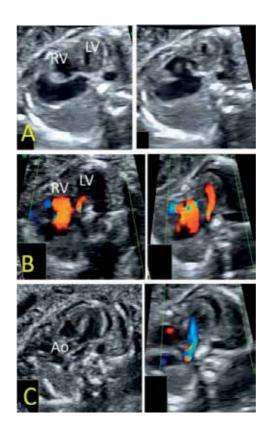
Hypoplastic left heart syndrome (HLHS), with discordance of the heart chambers, ventricular cardiomyopathy and hypertrophic left ventricle (A), markedly reduced filling at Doppler evaluation (B), fibroelastosis, and reduced aortic caliber and flow (C).
